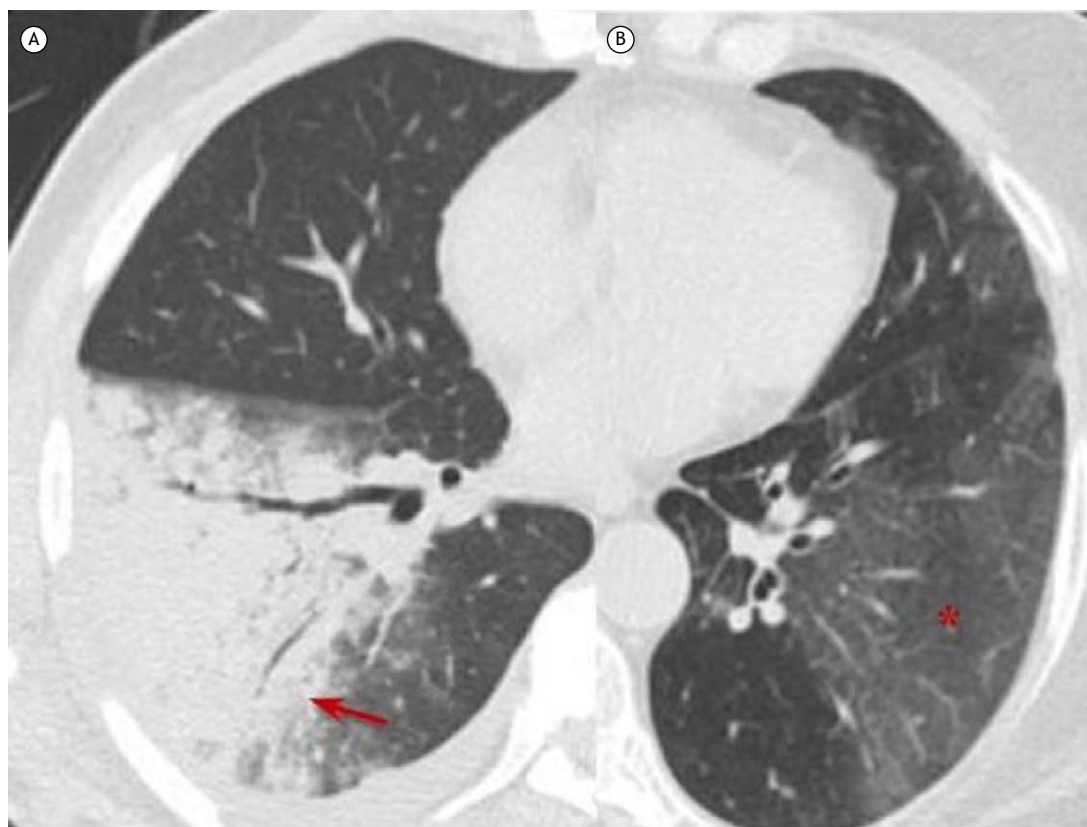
Axial CT scans with lung window settings showing parenchymal opacities that obliterate the contours of vessels and bronchi in the right lower lobe (arrow), indicating consolidation, together with an air bronchogram in the opacity (A), and parenchymal opacities preserving the contours of vessels and bronchi in the left lower lobe (asterisk), indicating ground-glass opacities (B).
